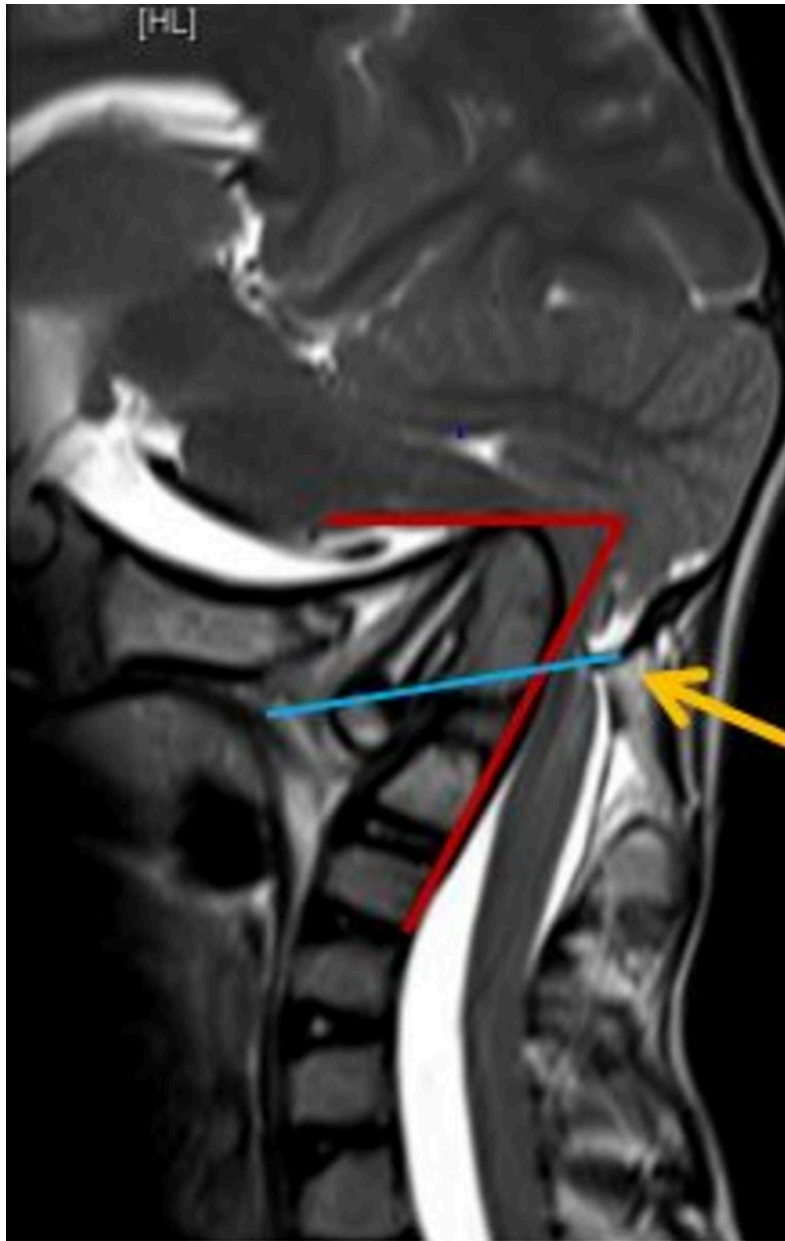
MRI sagittal section showing decreased clivus canal angle(red) , violation of Chamberlain's line (blue) and acute angulation compression of cervicomedullary junction(yellow).
